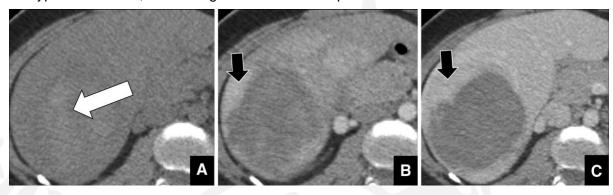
Hemorrhagic and necrotic HCA in a 35-year-old woman with history of oral contraceptives intake for 12 years who complained of abdominal pain after oral intake of nonsteroidal anti-inflammatory drugs. Axial CT images on (A) unenhanced, (B) arterial and (C) portal phases show a spontaneously hyperattenuating liver lesion in the right lobe (white arrow), with mild peripheral enhancement (black arrows) without any enhancement of the central core. Patient underwent right hepatectomy with diagnosis of inflammatory HCA with hemorrhagic and necrotic foci.
